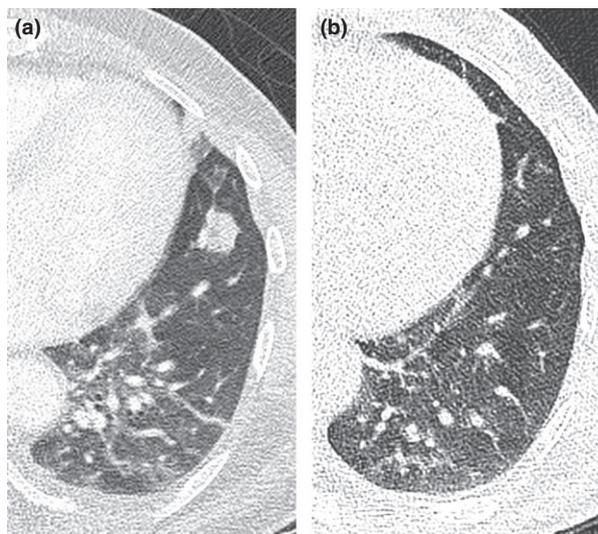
CT scan showing a left-sided nodule in the left lingula in 11/2010 (a) and normalization after therapy in 07/2011 (b).
